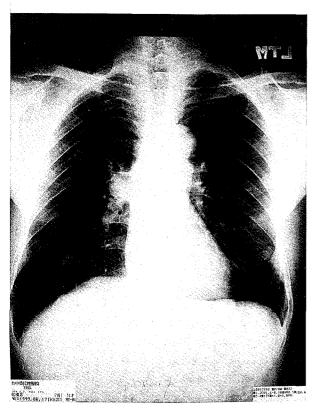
Chest roentgenogram, anterior posterior view, showing a well-defined nodular lesion in the right hilum with an obtuse angle attaching to the lung parenchyma.
